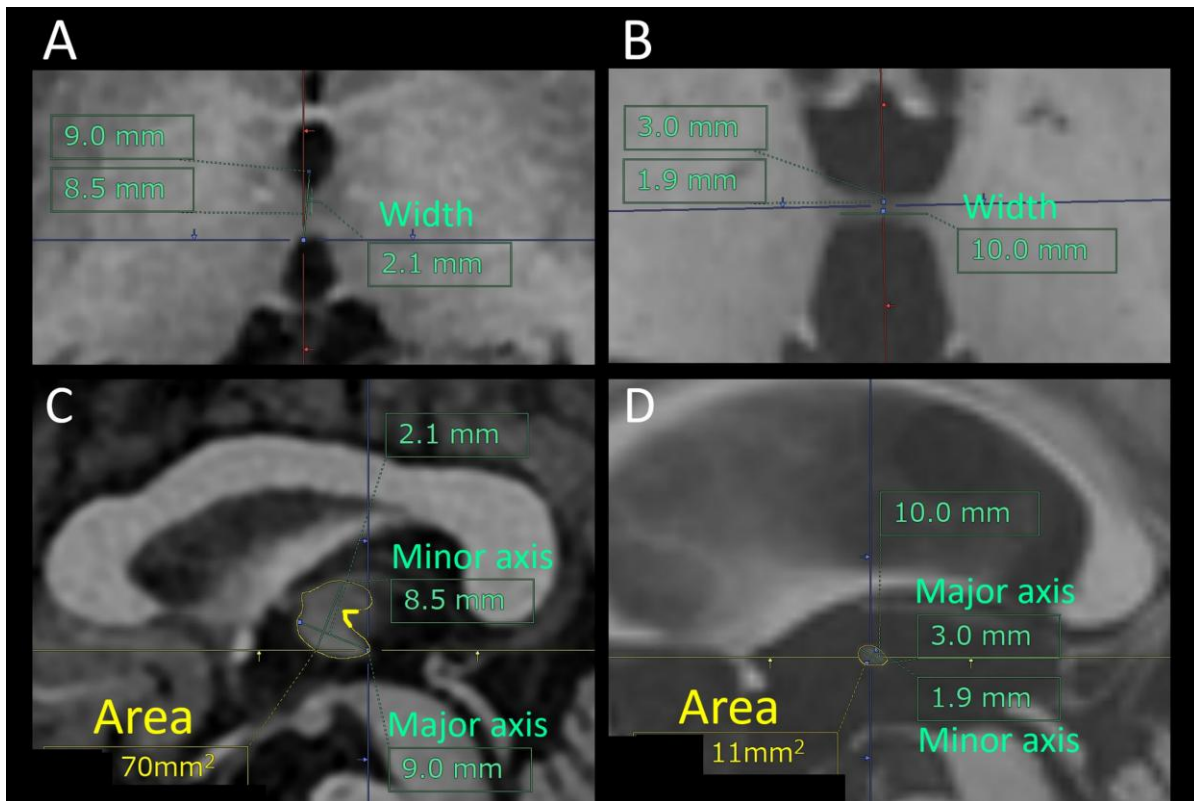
Measurement of the interthalamic adhesion (ITA). Representative 3D T1-weighted MR images in a healthy volunteer (A, C) and a patient with Hakim's disease (B, D). (A and B) Axial sections used to measure ITA width. (C and D) Sagittal sections used to measure ITA area, with major and minor axes indicated. The posterior recess (highlighted in yellow) is located in the ITA and extends toward the cerebral aqueduct. This structure is often visualized in healthy individuals with a prominent ITA
